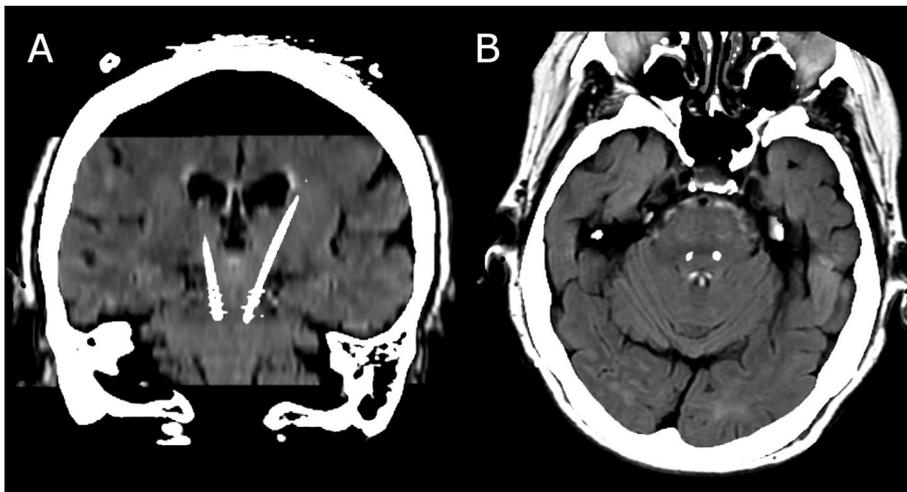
Example images from a patient with PD implanted with PPN deep brain stimulators. These images represent fusion of the postoperative computed tomography (CT) with the preoperative Magnetic Resonance Imaging (MRI) scans (Fluid Attenuation Inversion Recovery sequence). These demonstrate the brain electrodes implanted in the PPN region in two planes: Coronal (A) and axial (B).
